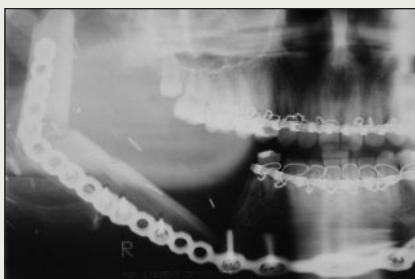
Immediate postoperative panoramic radiograph demonstrates the reconstruction of the mandible with a vascularized fibular flap and reconstruction plate.
